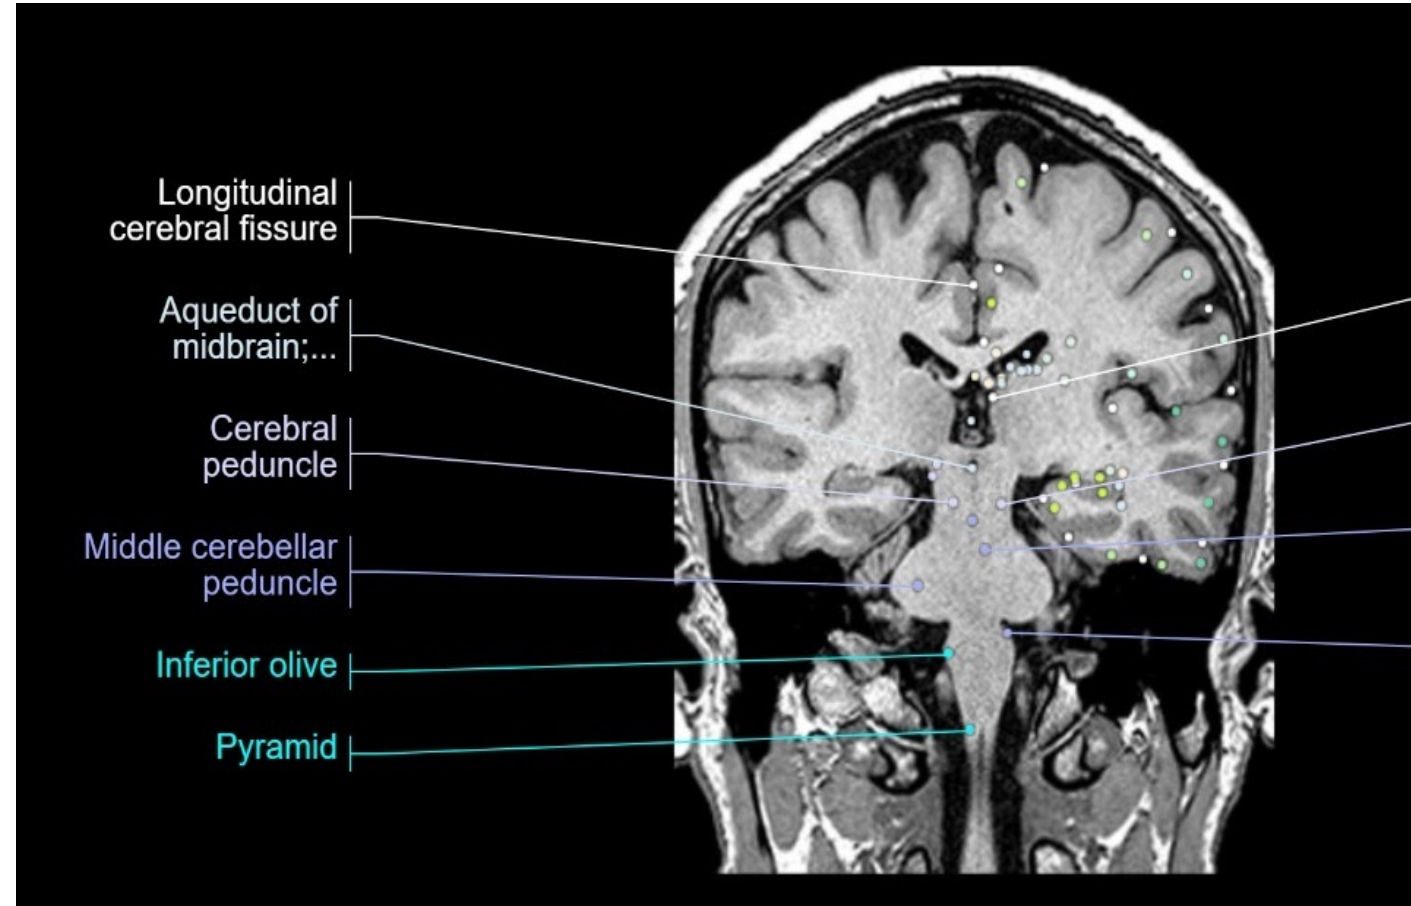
Image Ref: <https://www.imaios.com/en/e-Anatomy/Head-and-Neck/Brain-MRI-3D>
